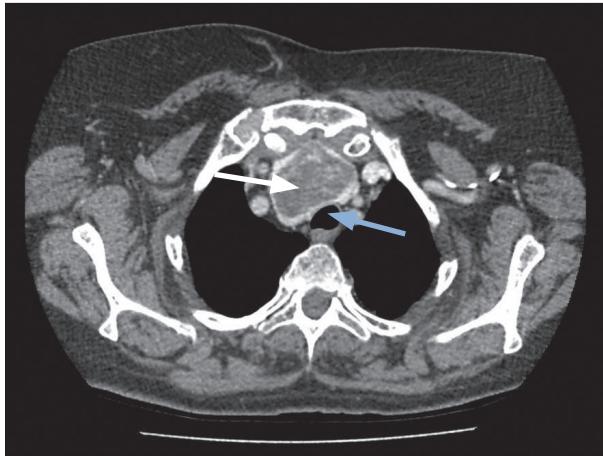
CT scan at the level of the manubrium. There is a large thyroid nodule (white arrow) located posterior to the manubrium and causing indentation of the anterior surface of the trachea (blue arrow)
